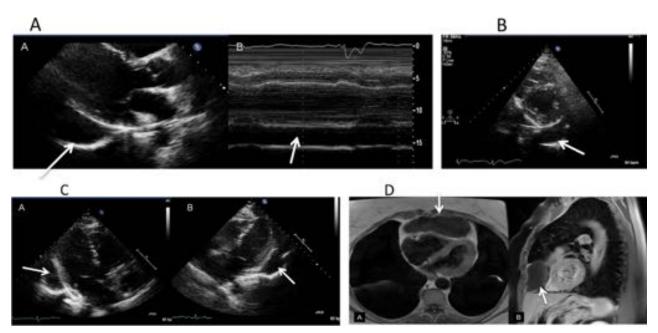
(A) Parasternal long-axis view (*left*) and M-mode (*right*) and short-axis view (B) (Videos 26 and 27; available at www. onlinejase.com) A large echo-free cystic structure posterior to the left ventricle. In the apical views (C), the lucent structure could be visualized by echocardiography only when the probe was rotated slightly and the ultrasound beam directed posterior from a standard apical four-chamber (*left*) and three-chamber view (*right*) (Video 28; available at www.onlinejase.com). On CMR (D), the pericardial cyst is well visualized. The T1W axial image (*left*) showing hypointensity in the loculated fluid in the anterior mediastinum, suggestive of cyst containing of simple fluid. The T1W sagittal view (*right*) after administration of gadolinium shows that the anterior mediastinal lesion is nonenhancing. The *white arrow* points to the pericardial cyst in all views.
